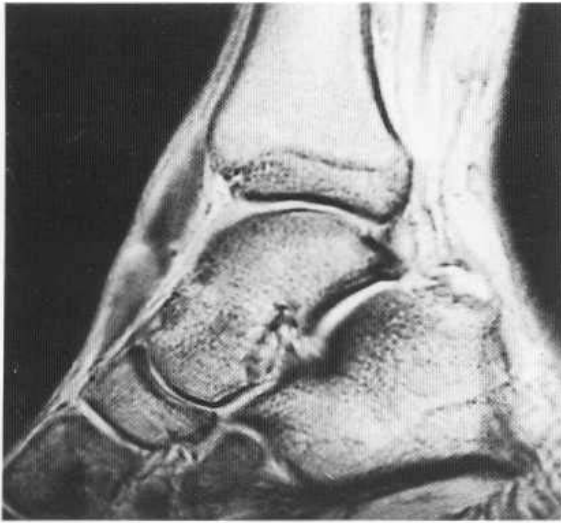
Thickening of the tibialis anterior tendon demonstrated at MRI.
